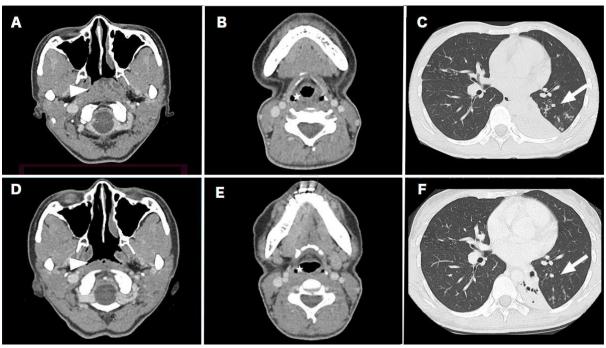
Selected CT images of neck and thorax acquired prior to and after 1 month of antitubercular treatment. Prior to treatment: A: white arrowhead shows left FOR mass with low density streaks within. B: white star shows aryepiglottic fold thickening. C: white arrow shows tree in bud nodules in apicoposterior segment of left upper lobe with adjacent left lower lobe lung collapse. Post 1-month antitubercular treatment: D: resolved left FOR mass. E: resolved aryepiglottic fold thickening. E: Lesser left upper lobe tree-in-bud nodules. Persistent left lower lobe collapse.
